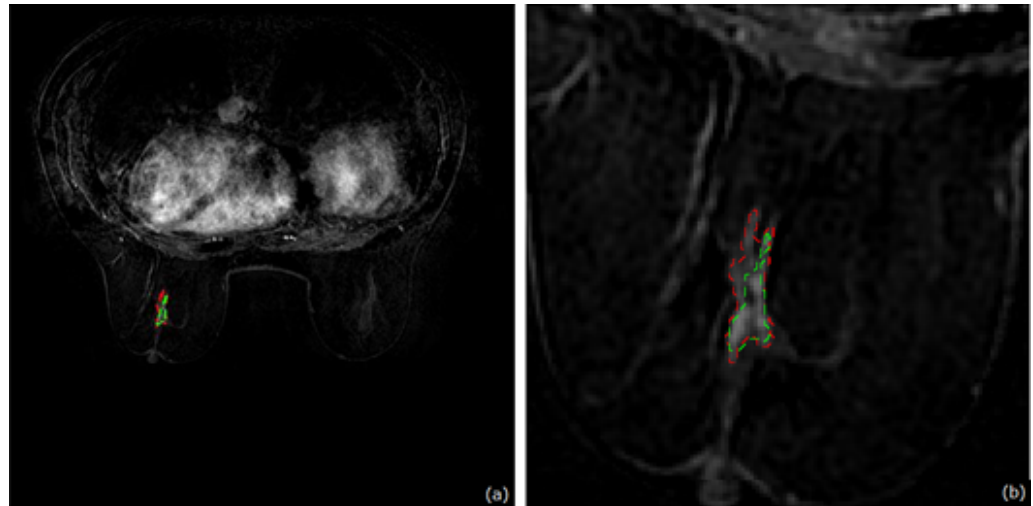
Case with an irregular lesion: (a) entire axial DCE-MRI slice; (b) crop of the slice shown in (a). Comparison between manual ground-truth (green) and automated segmentation (red).
